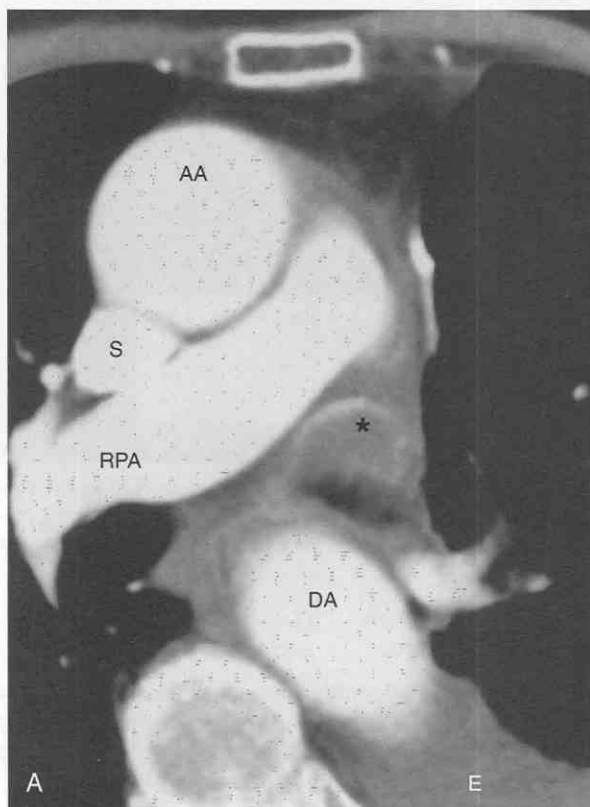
Clot in left atrial appendage in a patient with atrial fibrillation. Axial contrast-enhanced CT images at the level of the left atrial appendage (A and B) and at the level of the left atrium (C) show a low-density filling defect (*asterisk*) in the left atrial appendage extending into the left atrium. This is a typical location for left atrial thrombus. AA, ascending aorta; DA, descending aorta; E, pleural effusion; LA, left atrium; MPA, main pulmonary artery; RPA, right pulmonary artery; S, superior vena cava. The *open arrow* points to the right superior pulmonary vein.
